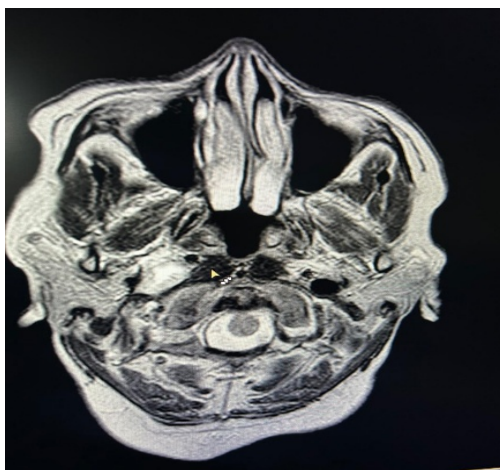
Axial T2-weighted MRI demonstrating a right jugular foramen lesion extending into the carotid sheath with characteristic separation of the internal carotid artery and internal jugular vein.
